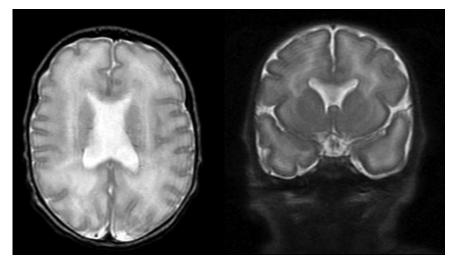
Axial (left) and coronal (right) brain magnetic resonance imaging shows slightly prominent lateral ventricles and absent septum pellucidum with marked T2 hyperintensities throughout the cerebral white matter (dysmaturity, hypomyelination) and a coarse gyral pattern (cortical immaturity).
